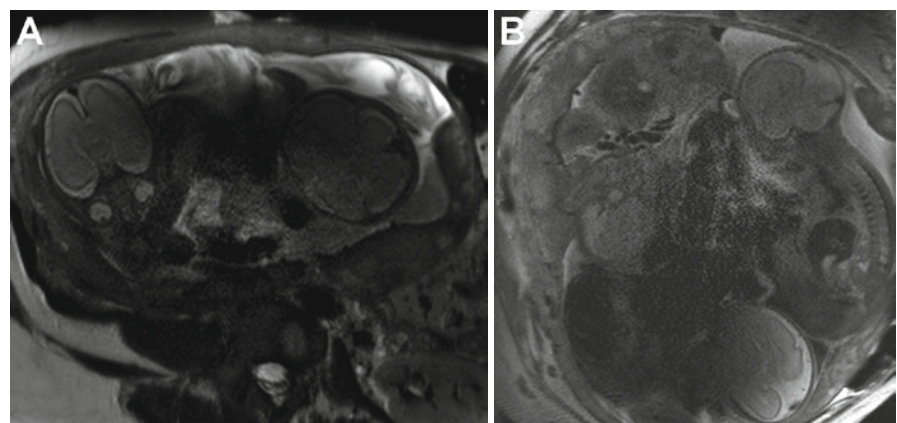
Standing wave and conductivity artifact in fetal MRI at higher field strength. Axial (a) and coronal (b) image of a combined appearance of the standing wave and the conductivity artifact in T2-weighted turbo spin-echo (TSE) sequences in a woman with a triplet pregnancy at 22 weeks of gestation measured at 3.0 T
